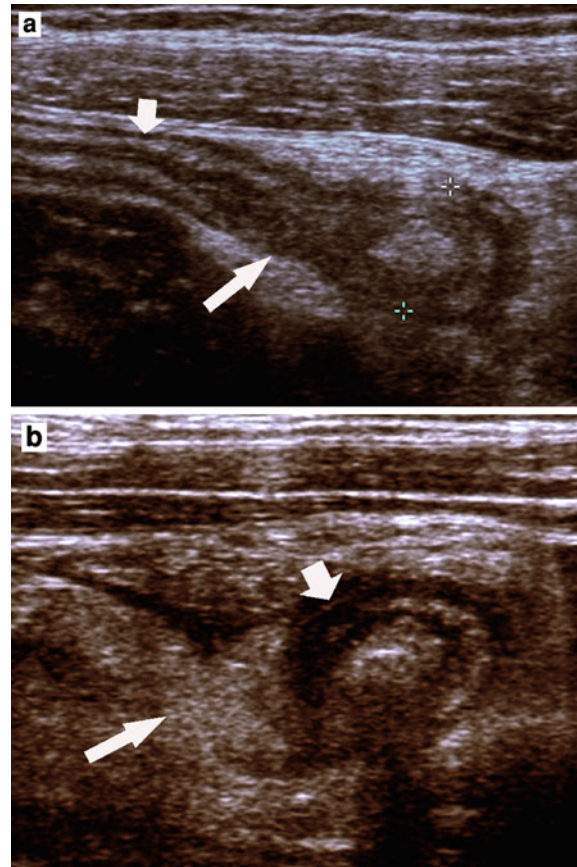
a, b Tip appendicitis with early gangrenous change. a is grayscale long-axis sonogram of appendix demonstrating normal proximal appendix with preserved echogenic submucosal layer (*short arrow*). Distal tip of appendix is enlarged (calipers); note focal loss of echogenic submucosal layer in distal third of appendix (*long arrow*). In b, transverse scan through short axis of appendix, note prominent echogenic inflamed periappendiceal fat (*long arrow*). Note focal loss of echogenic submucosal layer adjacent to this fat (*short arrow*). At surgery, tip appendicitis with early gangrenous change was noted
